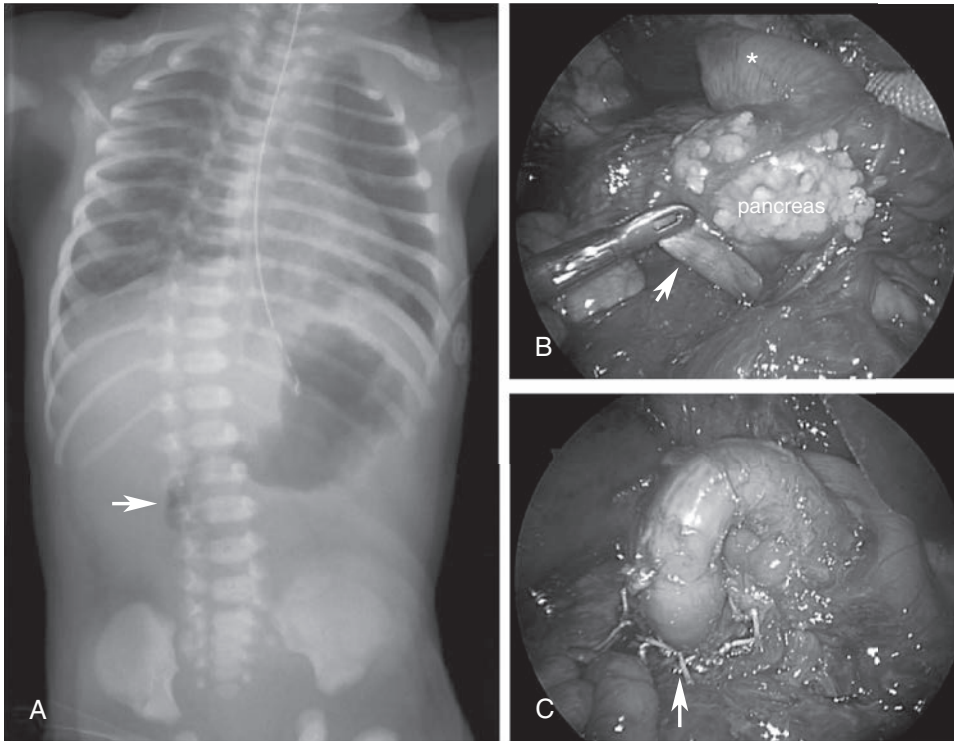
Duodenal atresia in a newborn. A, Abdominal radiograph shows classic “double bubble” sign. Orogastric tube is in stomach, and arrow shows air-filled proximal duodenum. B, Laparoscopic view of duodenal atresia. Asterisk depicts proximal dilated duodenum (compressed by instrument) and arrow shows small distal duodenum being elevated by a 3-mm bowel grasper. C, Completed anastomosis (arrow).
